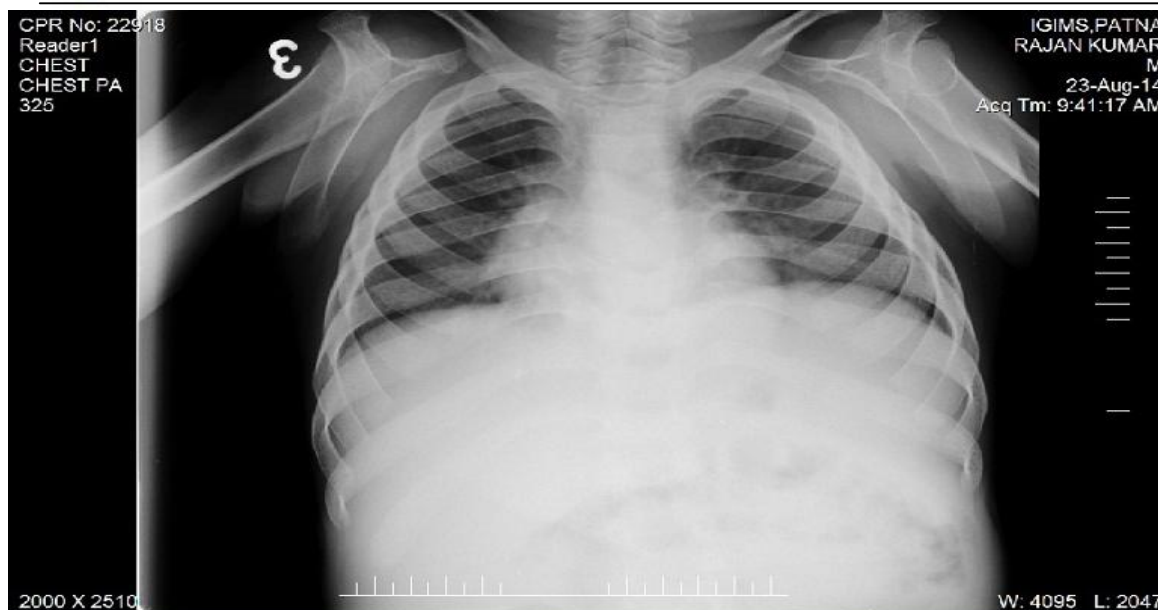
10-X-ray chest showing typical paddal/spatulated shape ribs(narrow vertebral ends and wider sternal ends).
